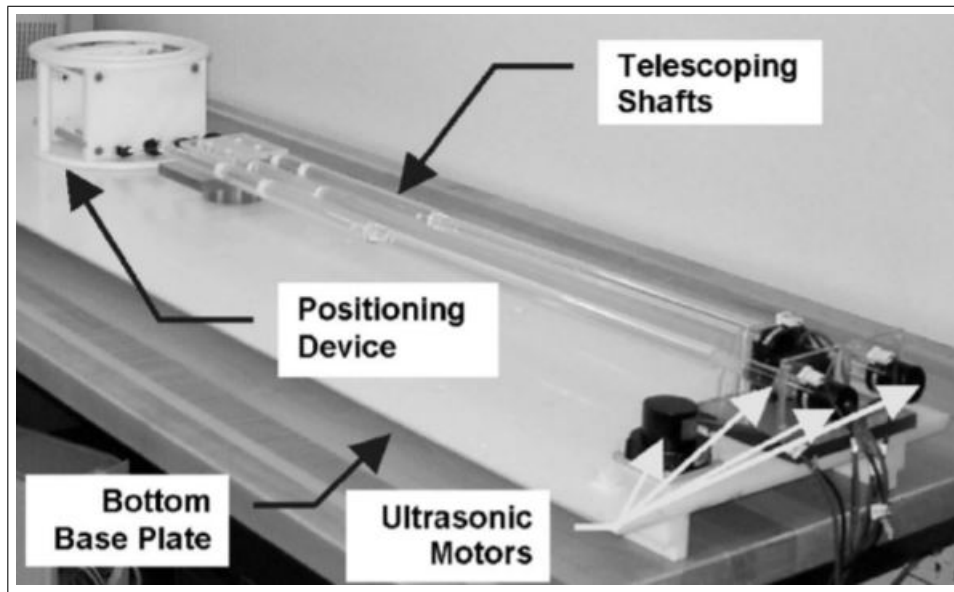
Ultrasonic Actuation[19]
